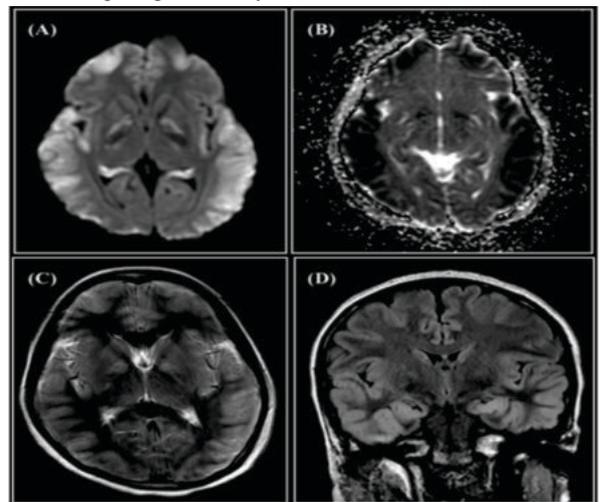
MRI scan of the brain. (A) Diffusion restriction seen in bilateral frontal and parietal cortex, subcortical white matter and hippocampi; (B) Low signal intensity on ADC; (C) T2 hyperintensities in same regions as in DWI; (D) FLAIR hyperintensities in bilateral temporal cortex, both hippocampi and in subcortical white matter.
